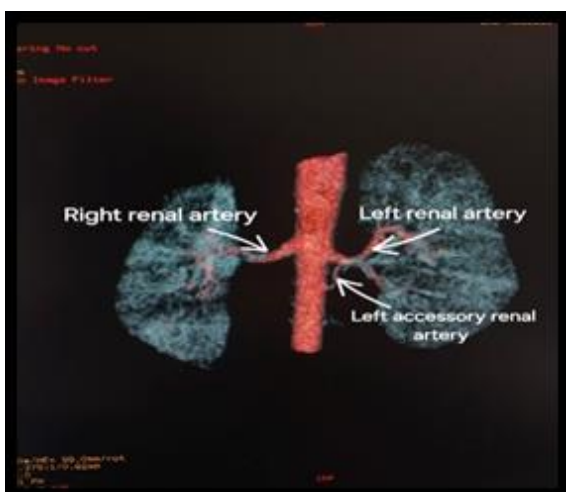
Computed tomography arterial phase images showing left accessory Renal artery, an extra renal artery entering the renal hilum
